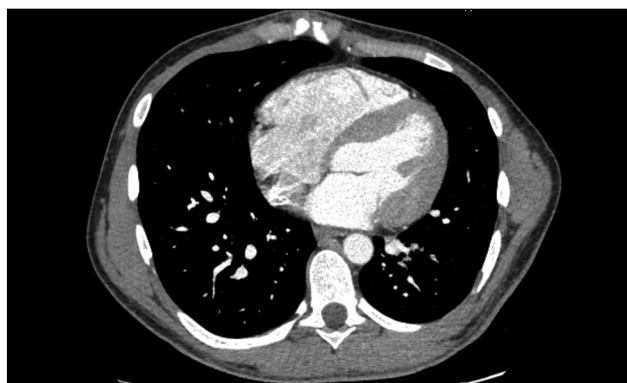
CT pulmonary angiography, axial view. Myocardial hypertrophy.
